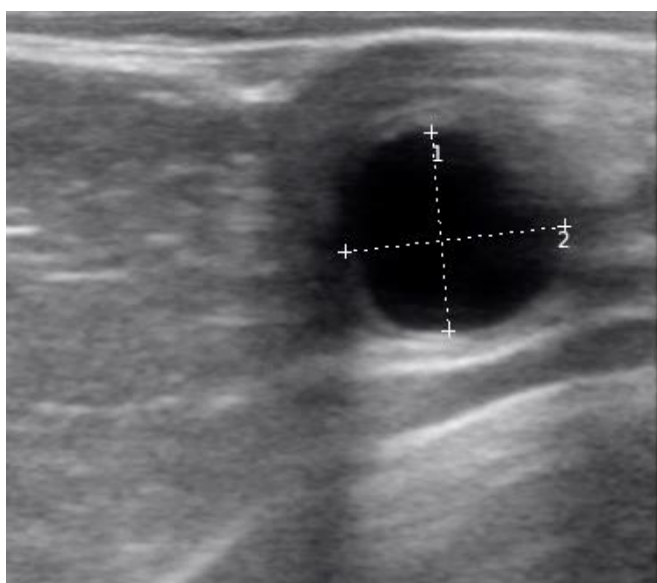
Ultrasonographic image of ovarian follicle
